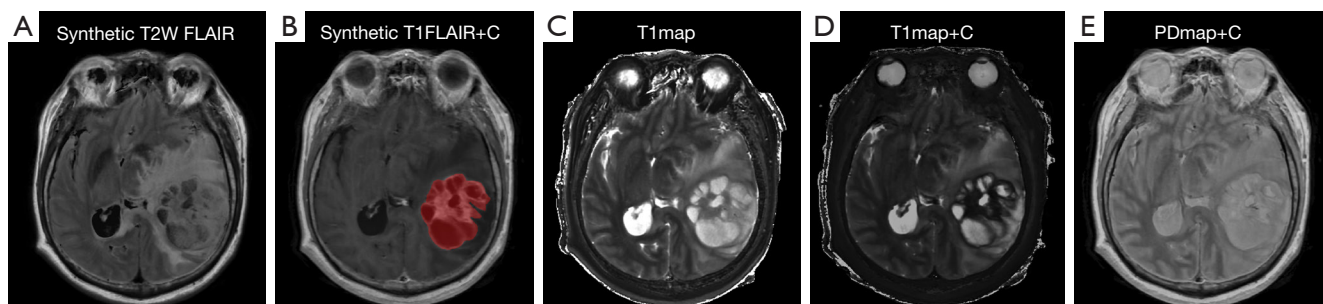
Representative images from a 59-year-old male patient with isocitrate dehydrogenase wildtype glioblastoma. The red mask on the synthetic T1FLAIR+C image (B) shows the lesion included in the volume of interest. Synthetic T2W FLAIR images enable visualization of tumor-associated edema, while T1FLAIR+C images facilitate observation of tumor enhancement and cystic. Radiological features: tumor location (temporal lobe), tumor size (58.62 mm), tumor border (sharp), enhancement style (irregular), enhancement degree (obvious), edema degree (31.78 mm), hemorrhage (no), cystic and necrosis ($\geq 50\%$), signal characteristics (heterogeneous), cross midline growth (no). (A,C-E) synthetic T2W FLAIR image, T1map, T1map+C, and PDmap+C at the same level as figure (B). T2W FLAIR, T2-weighted fluid-attenuated inversion-recovery; T1FLAIR+C, post-contrast T1 fluid-attenuated inversion-recovery; T1map+C, post-contrast T1map; PDmap+C, post-contrast PDmap.
